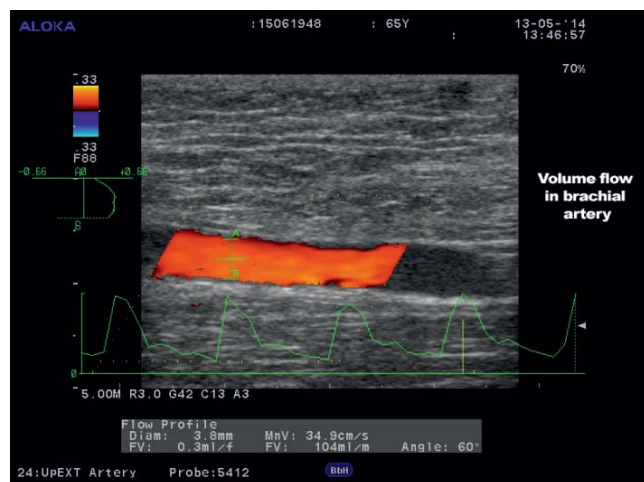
Duplex ultrasound imaging of the flow in the brachial artery supplying the hemodialysis fistula. Volume flow = 104 ml/min, at a beam angle = 60°.
